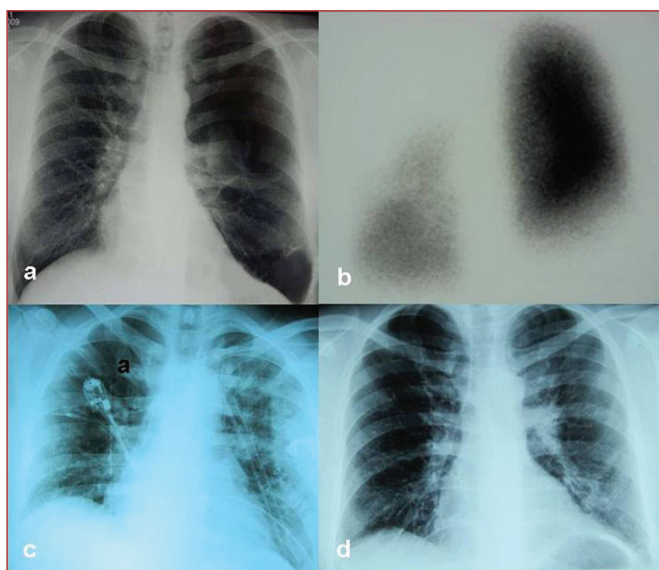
Hyperinflation of the left lung on chest X-ray (a), there were no perfusion and ventilation for left upper lobe on V/Q scintigraphy (b), infiltration was seen on the left side due to re-expansion of the compressed lung on the first postoperative day (c), normal chest X-ray after seven days from resection (d).
